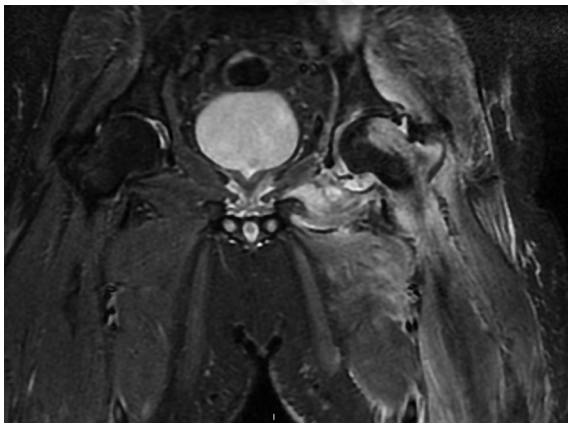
Pyomyositis of right buttock and pelvis; magnetic resonance imaging coronal short-time-inversion-recovery image showed multiple abscesses in the right ileopsoas muscle, in the right *obturator externus* muscle, in the right *pectineus* muscle and bone marrow edema in the right ilium bone.
